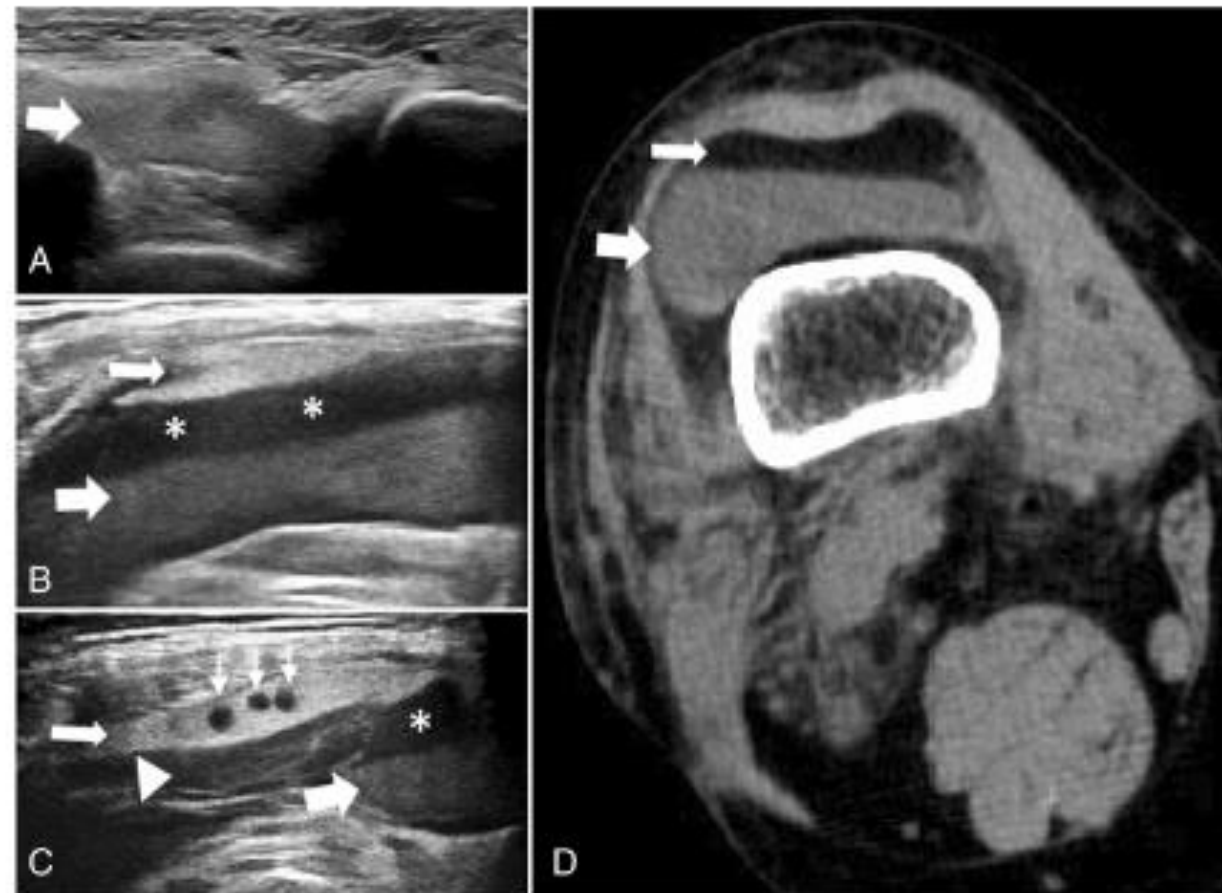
Ultrasound-CT diagnostic correlation. A, Bimalleolar fracture: Heterogeneous hemarthrosis (arrow). B,C, Tibial plateau fracture with lipohemarthrosis and double fluid–fluid levels. Layers (superficial to deep): Fat (thin arrow), serous fluid (*), cellular debris (thick arrow). C, Hyperechoic fibrin strands (Δ) and fat-blood spheres ($\rightarrow$). D, Axial CT: Lipohemarthrosis showing fat (thin arrow) and cellular layers (thick arrow). Indirect signs: subperiosteal hematoma, peri-fracture hematoma, subcutaneous soft-tissue.
